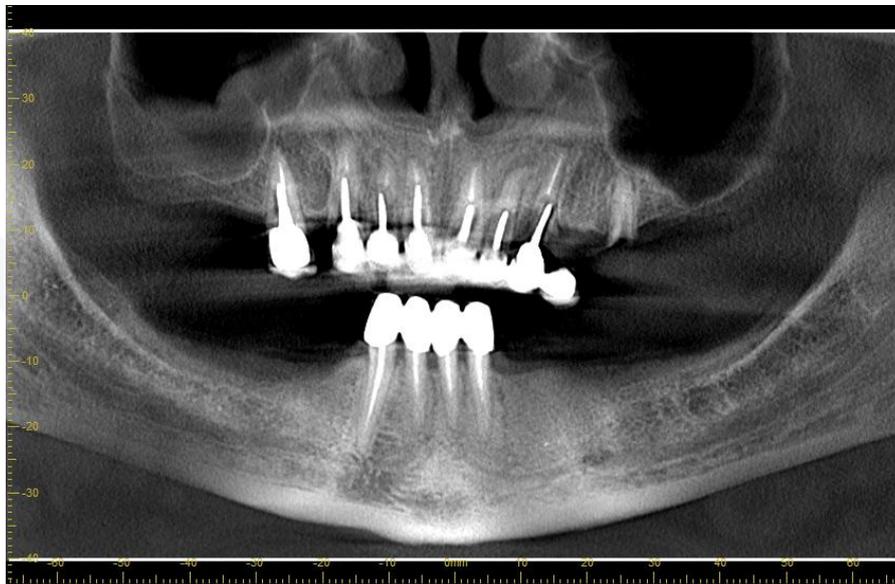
Orthopantomogram before implantation treatment.
